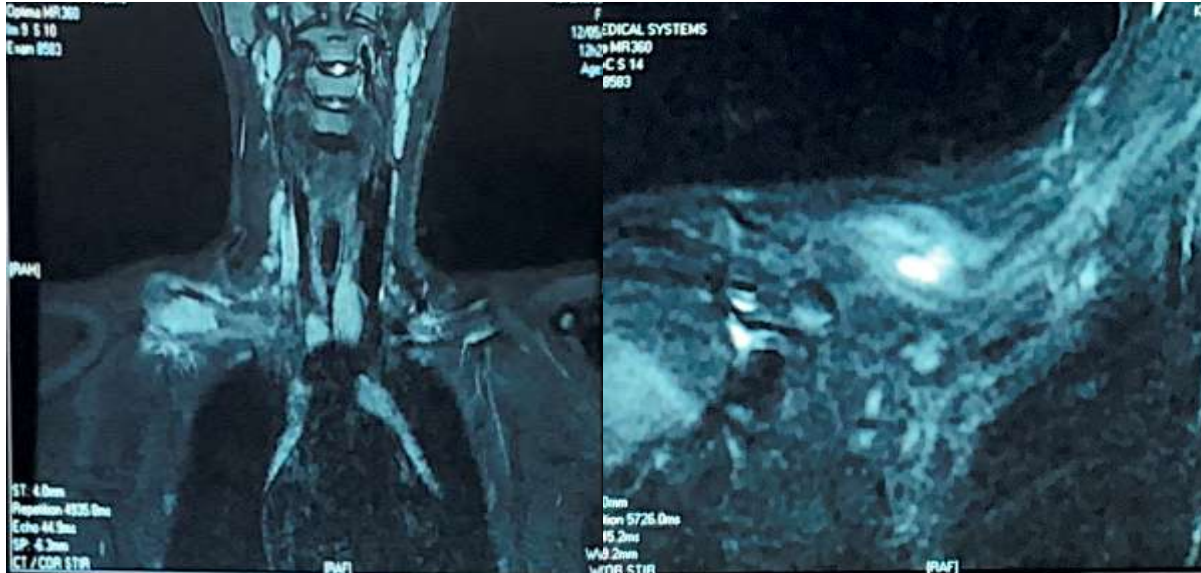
MRI findings in our patient.
